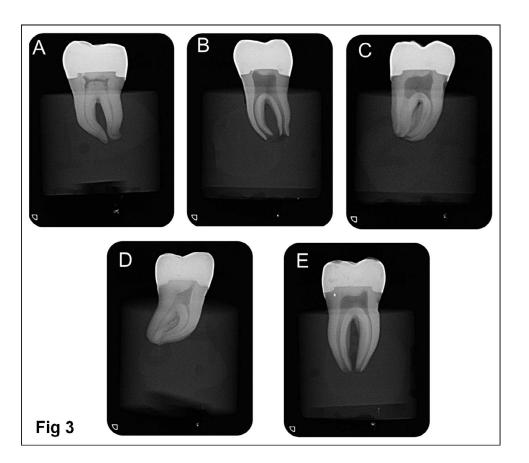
Radiographs of restorative techniques. (A): SDR/EST-X. (B): TEC. (C): VBF/CHA. (D):, FBF/Z350. (E): Z350.
